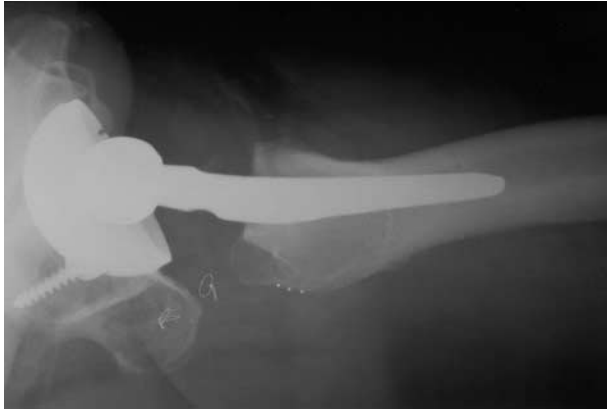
Early failure of each repair (piriformis, triceps coxae, and obturator externus muscle) on the axial radiograph of the first postoperative day. The distance between wire knot and tantalum ball is >2.5 cm.
